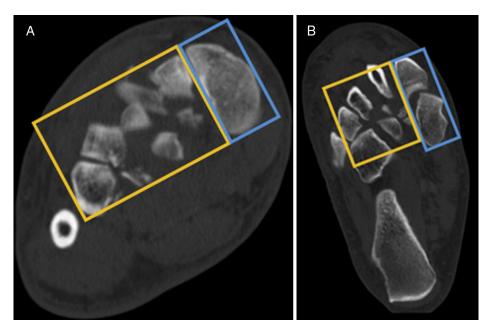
Postreduction computed tomography scans. (*A*) Coronal and (*B*) axial computed tomography images revealing primary dislocation to the first tarsometatarsal joint (*blue box*) and comminuted intra-articular fractures to the second through fourth tarsometatarsal joints (*orange box*).
